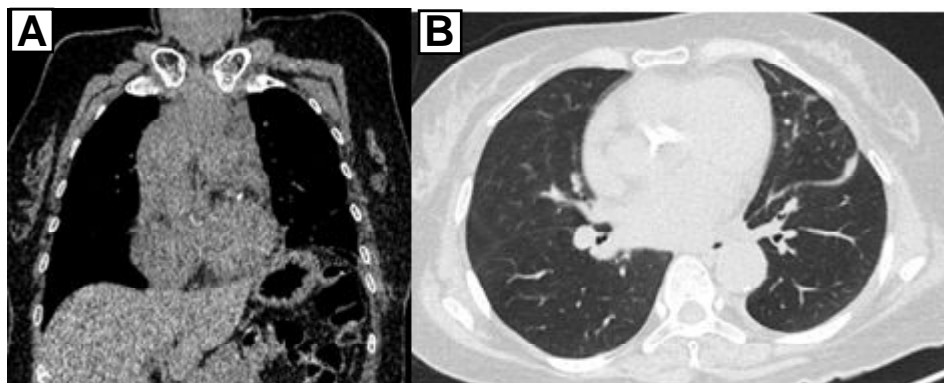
Coronal (A) and axial plane (B) of chest CT from a follow-up thoracic CT scan postoperatively. There is no intrathoracic cystic mass is identified in the lungs or mediastinum. Minimal pleural effusion is observed in the left pleural cavity. CT, computed tomography.
